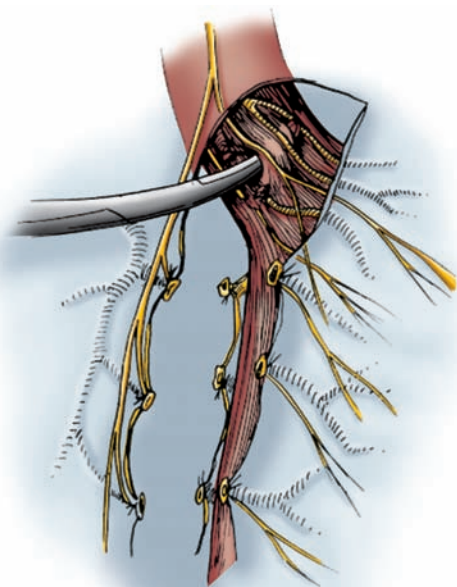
Anterior gastric branches of the anterior vagal trunk running downward on the anterior surface of the esophagus are gently lifted with a hemostat and either ligated or clipped before being divided or destroyed with diathermy. (Redrawn, with permission, from Johnston D. Vagotomy. In: Schwartz SI, Ellis H, eds. *Maingot's Abdominal Operations*. 8th ed. Norwalk, CT: Appleton-Century-Crofts; 1985. After R.N. Lane.)
